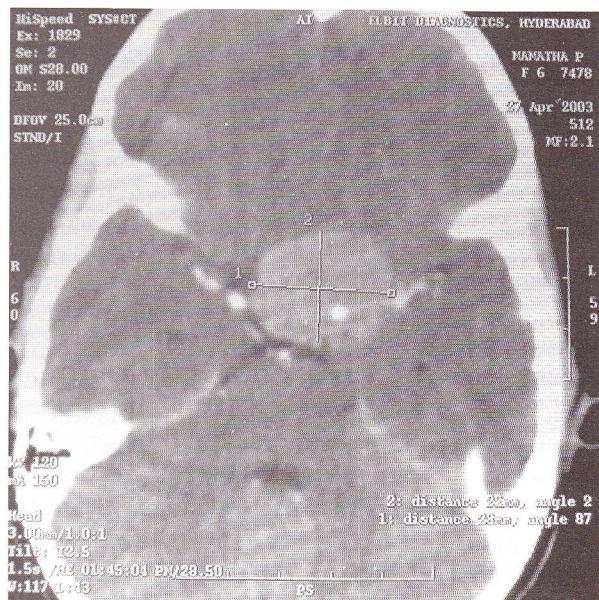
Children with atypical presentation are also more likely to have extraocular spread. CT scan of the same child in Figure 108.3 showing the presence of a parasellar lesion
